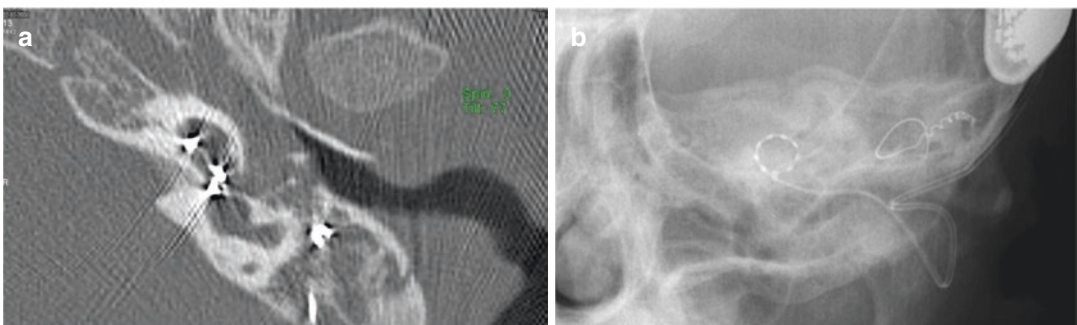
Case 23.2. (a) Tomography showing fluid filling the middle ear on the side with CI. (b) Postoperative X-ray showed FORM 24 electrode inside IP-I cochlea
